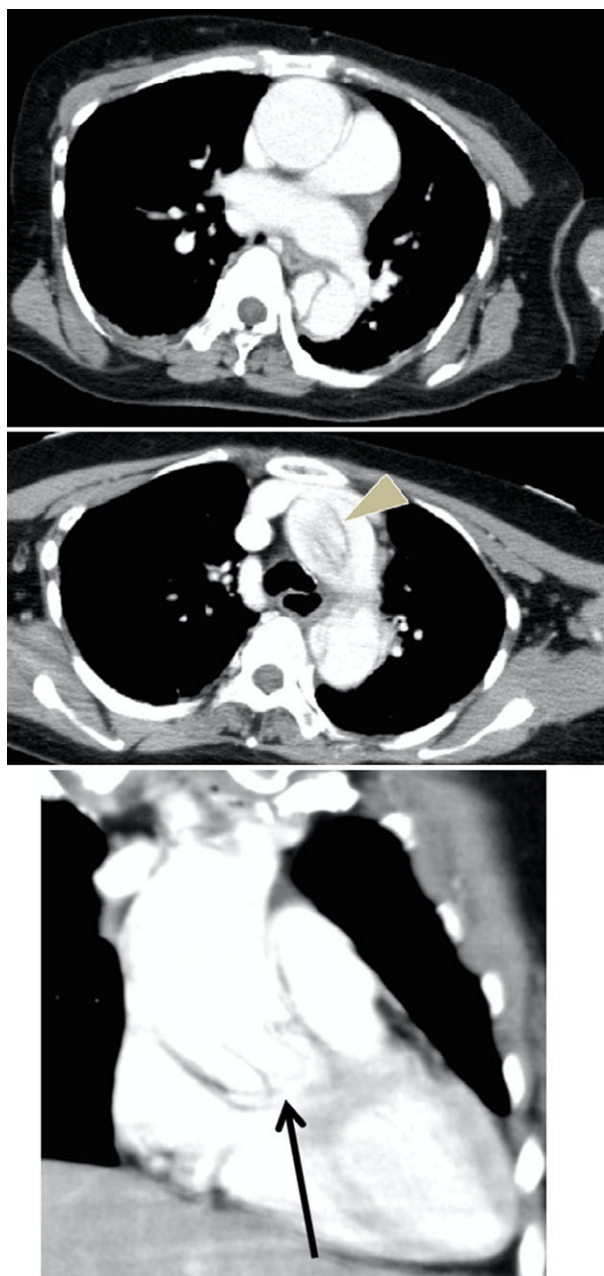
Enhanced computed tomography scans of a 58-year-old woman with sudden-onset chest discomfort and loss of consciousness, showing no obvious intimal flap at the proximal ascending aorta but some linear artefacts at the aortic root (arrow). Additionally, the intimal flap was observed from the aortic arch (arrowhead), and it extended to both common iliac arteries.
